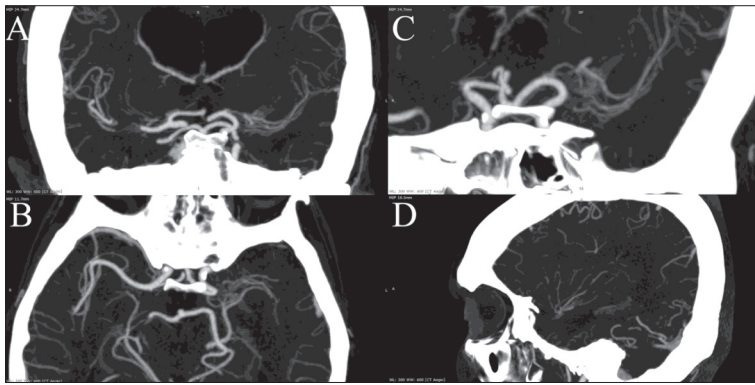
Computed tomography angiography maximum intensity projection reconstructions, A – coronal, B – axial, and C – oblique projections show multiple “twig-like” arteries arising from terminal part of left internal carotid artery, forming network in place where the M1 should be; D – sagittal projection demonstrates normal arborization of the left middle cerebral artery with branches that are slightly less filled with contrast agent
